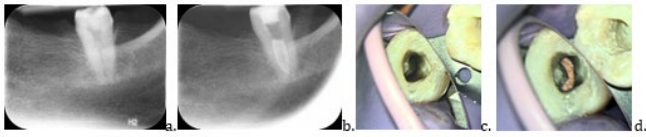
Clinical example of a C-shaped left mandibular second molar a. preoperative radiograph b. postoperative radiograph c. clinical image d. filled root canals.
